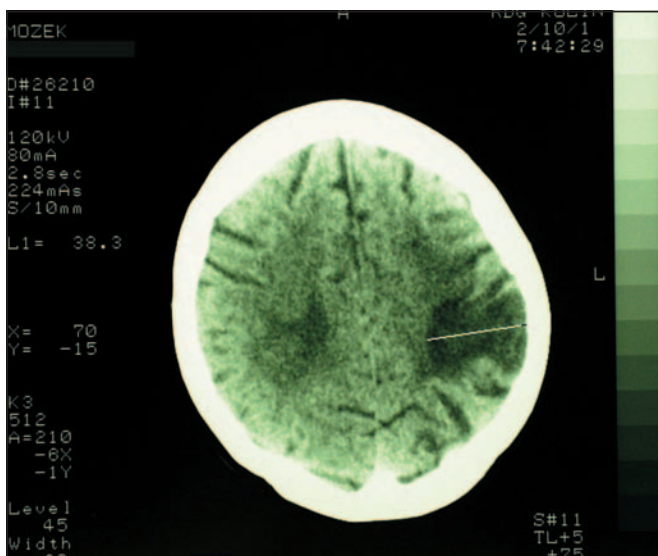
CT of the brain – enlargement of the malacic focus in the left hemisphere
